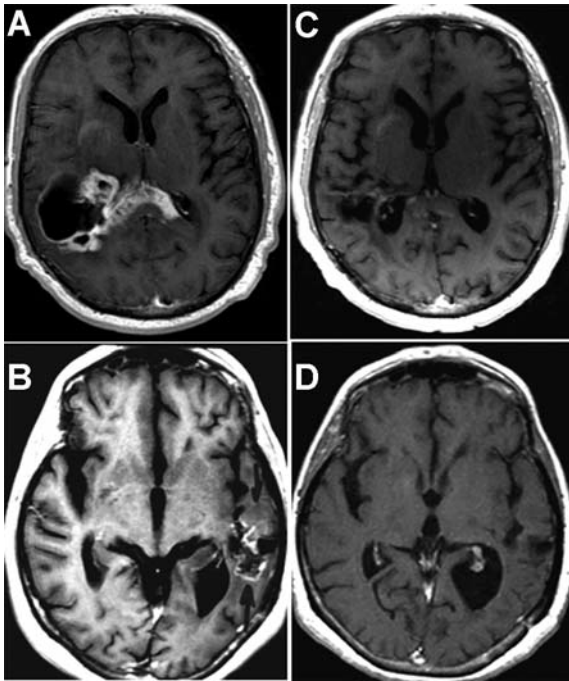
Effect of intranasal POH treatment in recurrent GBM. Representative brain image (MRI) of a patient with recurrent primary GBM. Decrease in the tumor size between the initial MRI (A, B) and 6 months after treatment (C, D).
